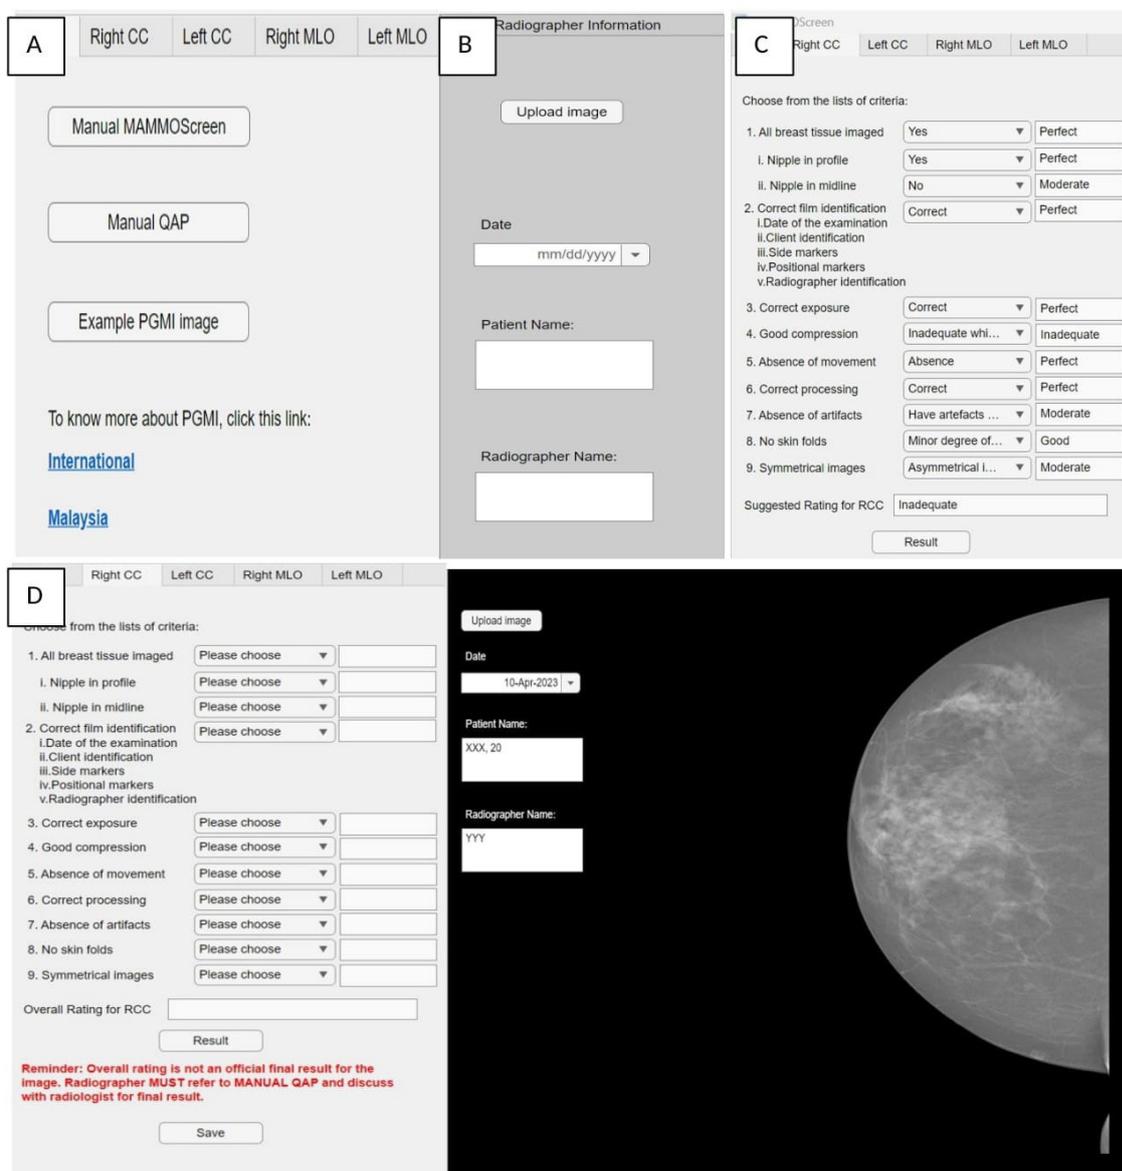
Screenshots of the MAMMOScreen window with (A) help tab, (B) patient and radiographer information tab, (C) Right CC tab and (D) image imported in MAMMOScreen
